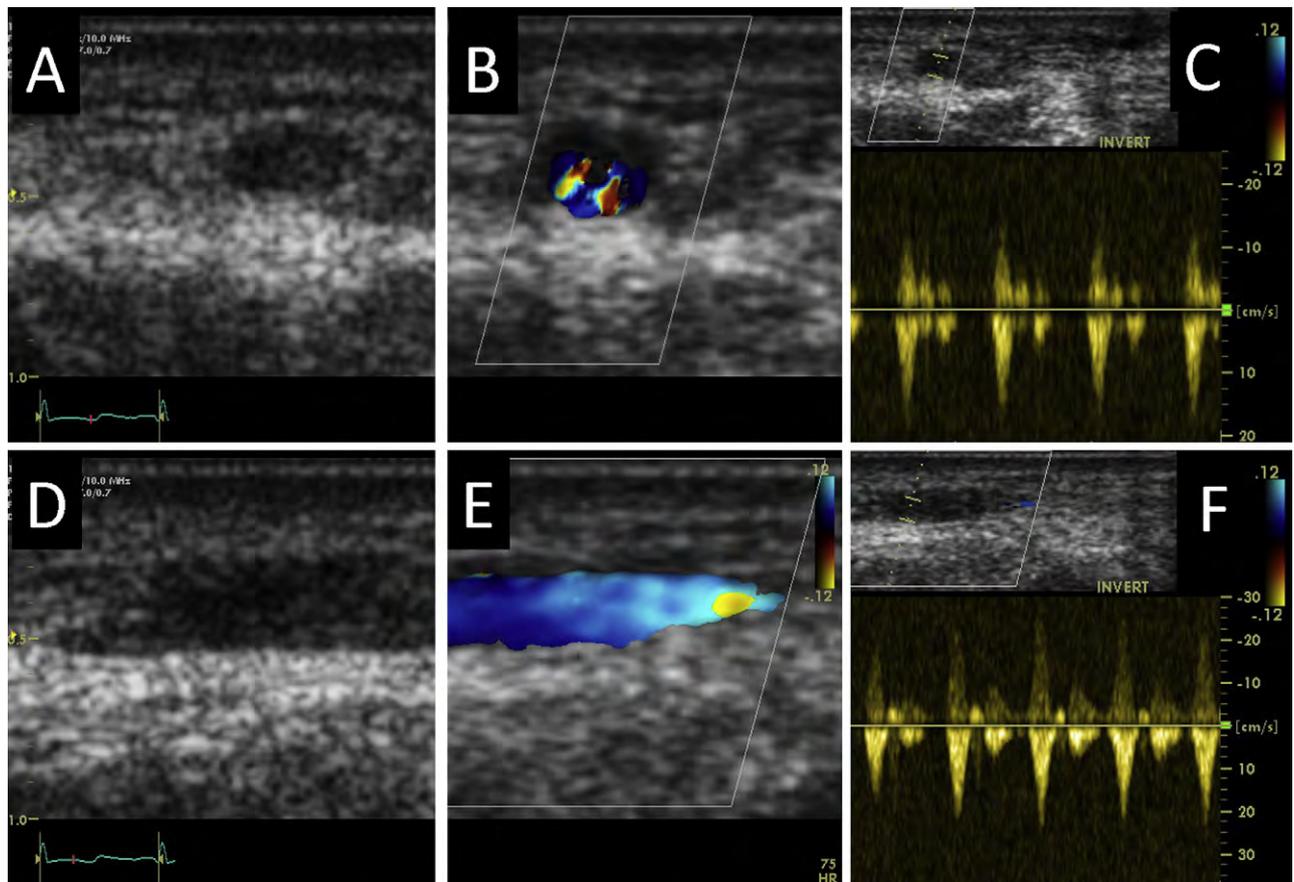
Surface ultrasound imaging of the radial artery with a small probe. Two-dimensional ultrasound in SAX (A) and LAX (D) orientations. Doppler ultrasound demonstrating systolic flow with color Doppler (B,E) and pulsed-wave Doppler in SAX (C) and LAX (F) orientations, respectively.
